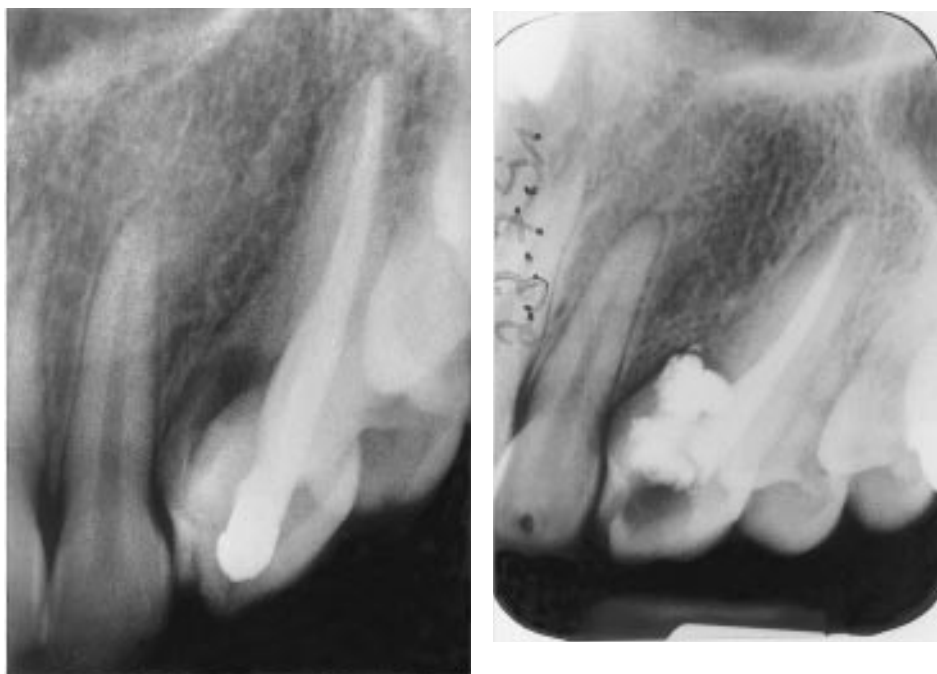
(a) Radiograph of tooth 23 showing a bizarre lateral coronal invagination which seems to be open to the lateral periodontium. The main root canal was root canal treated, but no communication to the invagination could be detected. (b) As no access to the invagination was found coronally the invagination was treated surgically. Probably root canal treatment of the main root canal would not have been necessary.
